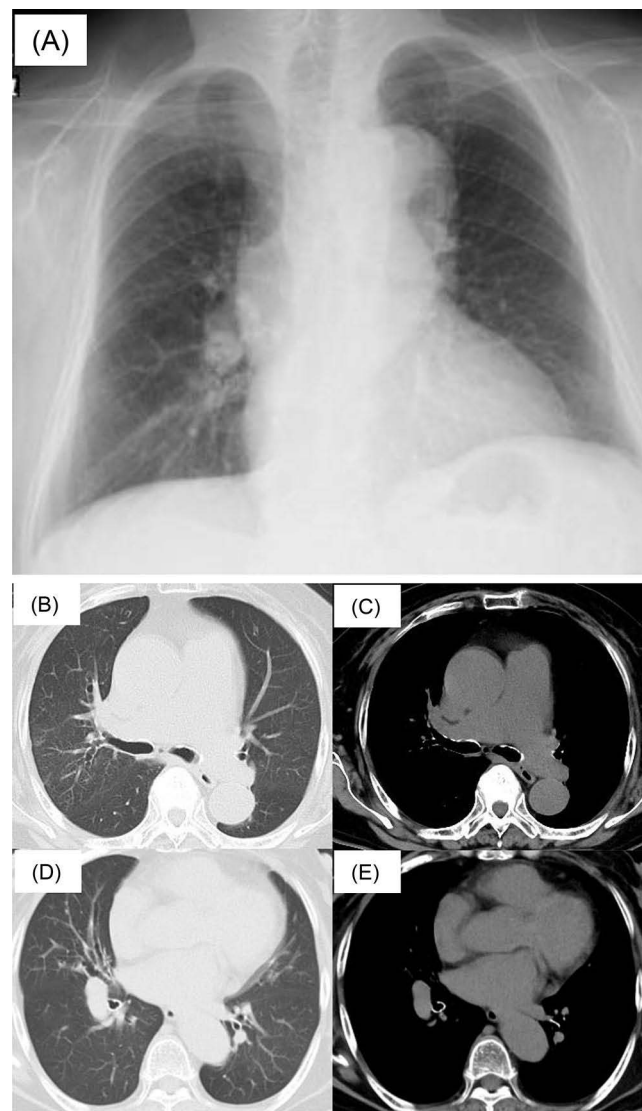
Findings on chest X-ray and CT after treatment with dupilumab. (A) Chest X-ray shows disappearance of the decreased density in the upper lung field. (B–E) Chest CT shows disappearance of consolidation on the lung window setting and high attenuation structures on the mediastinal window setting in the right upper lobe.
